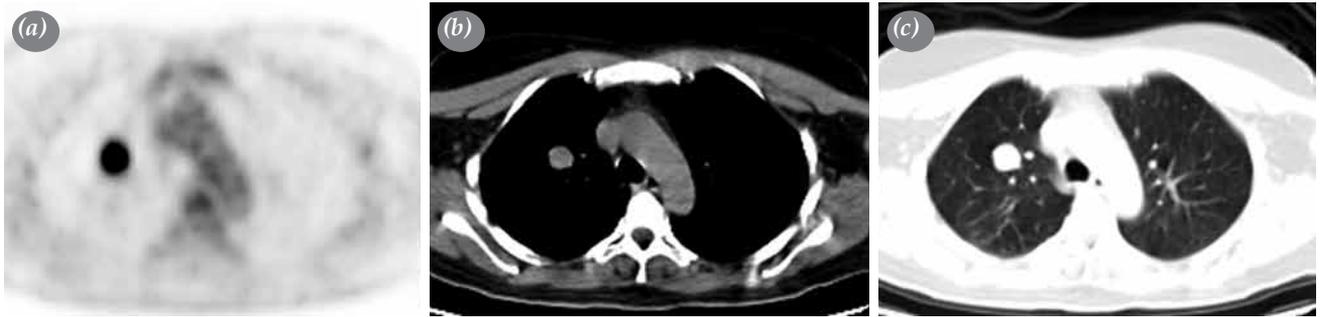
(Patient 13; 45 years old, female) Axial slice positron emission tomography (a), CT in soft tissue window (b) and in lung window (c) images showing an increased FDG accumulation in the lesion in right upper lobe in 24 mm diameter (SUV_{max} : 6.17). After wedge resection, the diagnosis was reported as an inflammatory pseudotumor.
